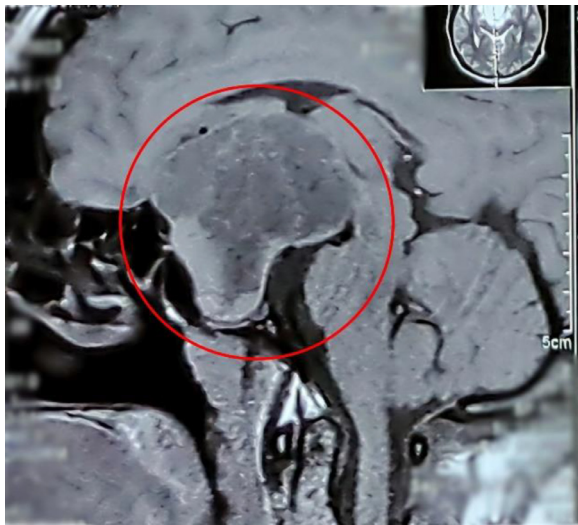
This sagittal T1-weighted postcontrast MRI of the brain, specifically focusing on the sella turcica region, reveals a large, homogeneously enhancing mass centered within the sella turcica, consistent with a pituitary macroadenoma. The mass exhibits clear, well-defined borders and appears to expand the sella, with extension into the suprasellar region (marked by circle).
